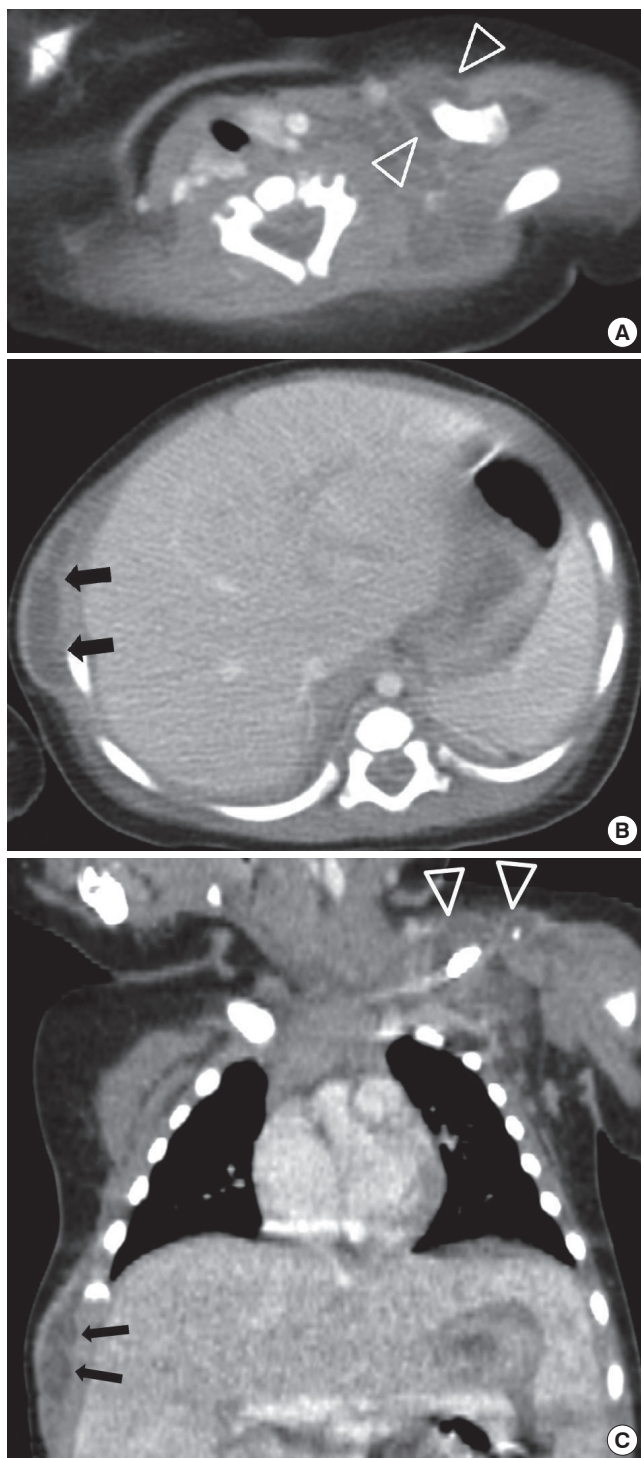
Axial computed tomography scan shows multiple abscesses (open arrowheads and arrows) around the left clavicle (A and C) and right anterior chest wall (B and C).
